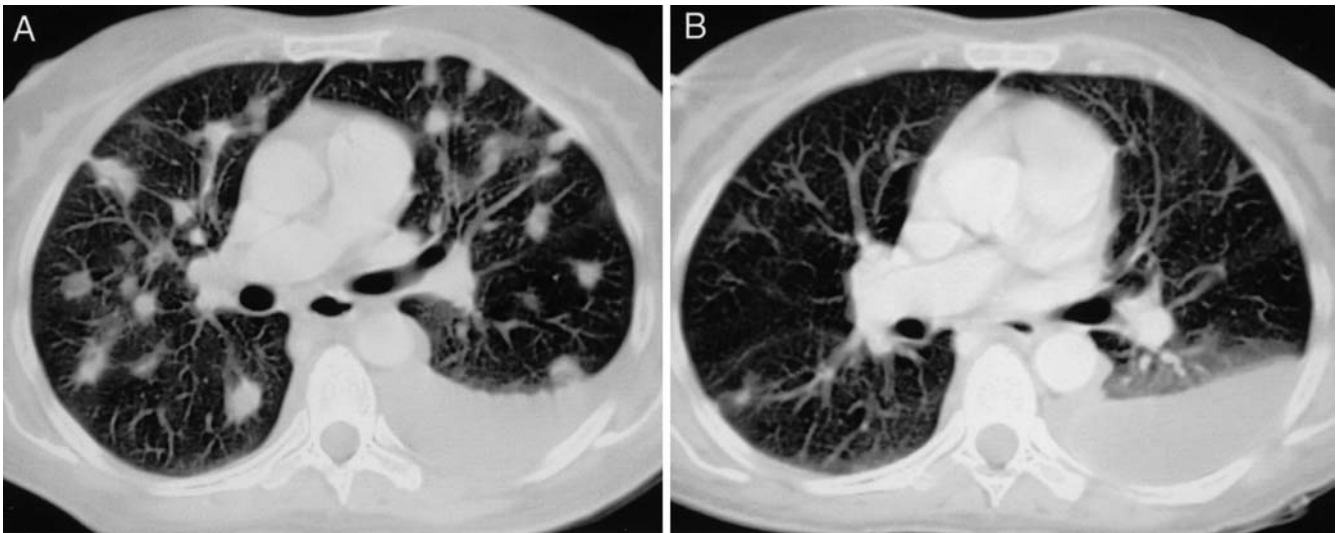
Chest CT scan. A Baseline: multiple nodules disseminated in both lungs and left pleural effusion. B After 24 weeks of therapy with posaconazole: nearly complete disappearance of the pulmonary nodules; persistence of a left pleural effusion
